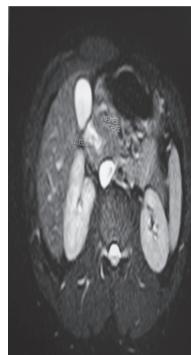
MRI abdomen T2-weighted axial image at the level of pancreas shows pancreatic tissue surrounding the duodenum.
